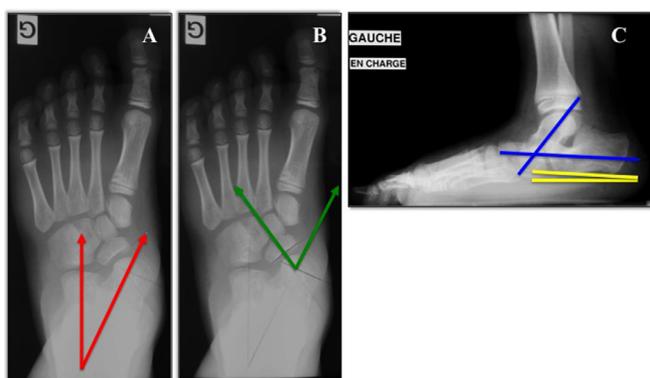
Radiographic analysis conducted on anteroposterior (AP) and lateral weight-bearing radiographs: (A) talocalcaneal, (B) talonavicular coverage angle, and (C) talocalcaneal divergence and calcaneal pitch.
